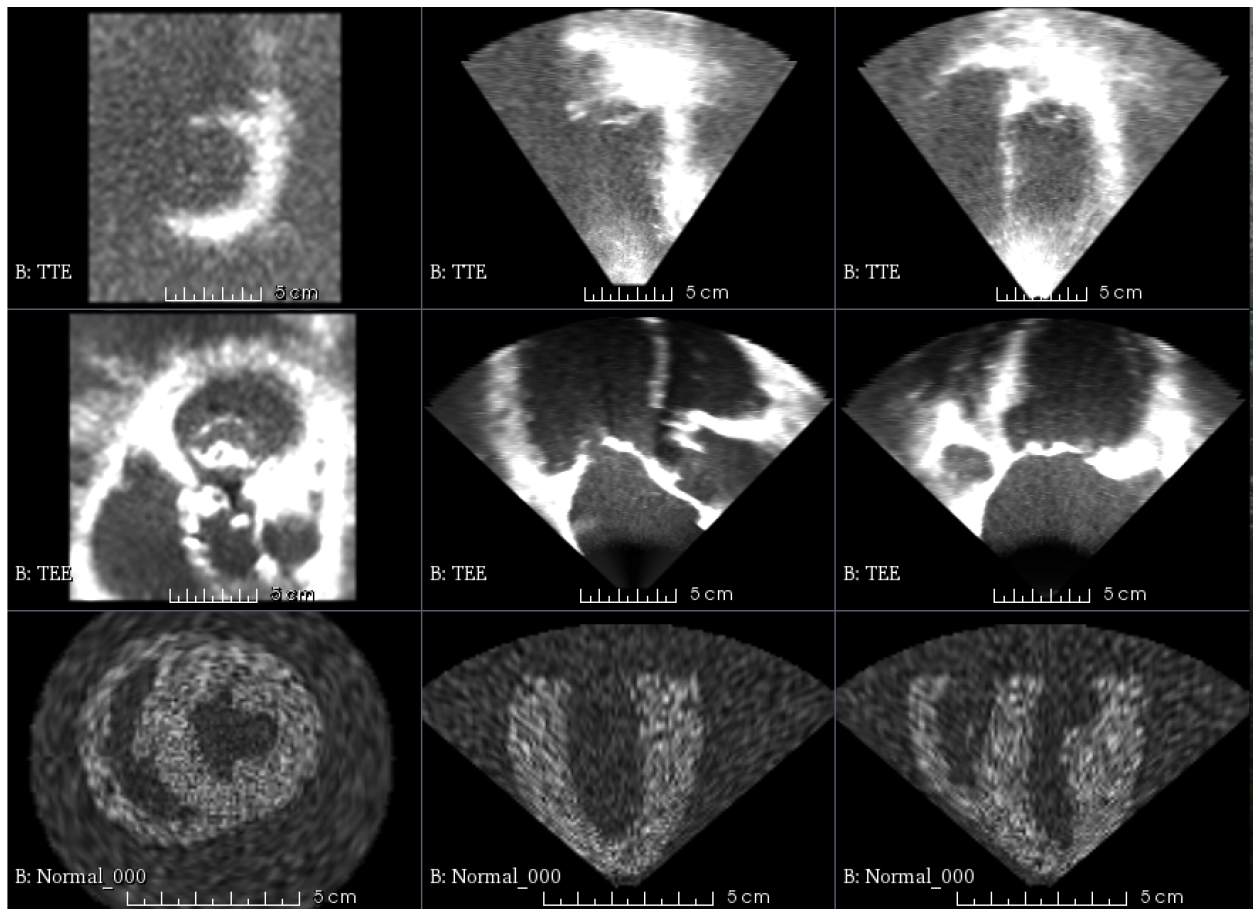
Dataset provided. (TTE) Transthoracic echocardiography. (TEE) Transesophageal echocardiography. (Normal\_000) Synthetic image.
